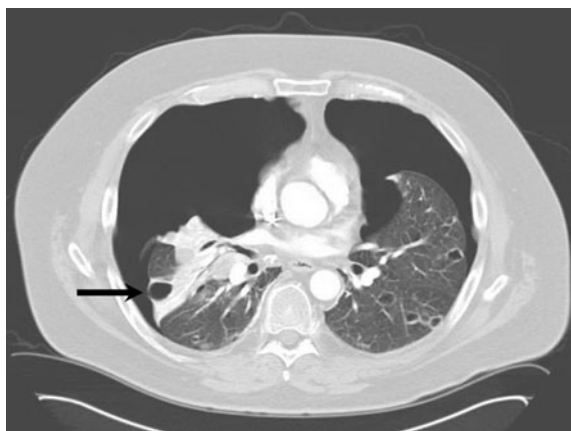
Chest computed tomogram demonstrating bilateral pneumothorax with multiple cysts at prior sites of nodules after 3 weeks of sunitinib therapy (*Arrow*: ruptured cyst)
